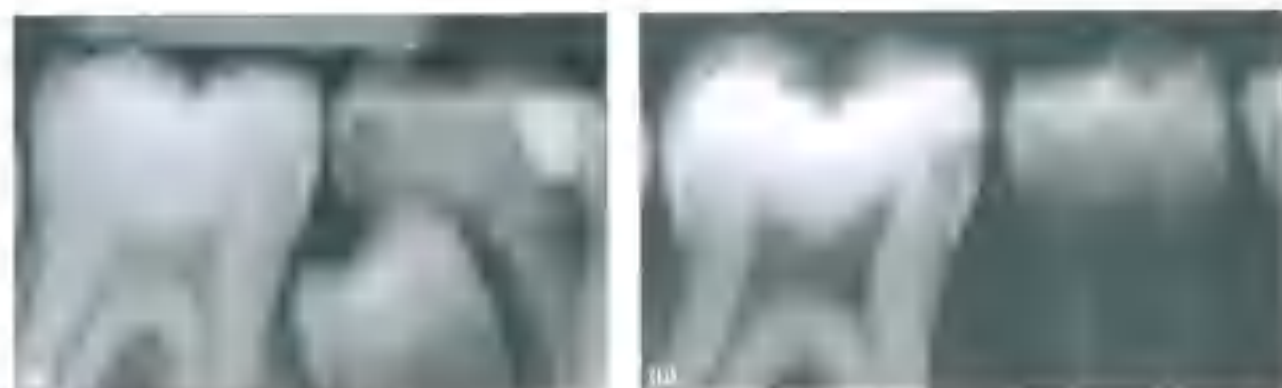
Two magnified radiographs showing caries lesion progression over 4 years in the same patient. (a) Dentin caries lesion in the distal surface of lower right primary second molar – a condition that increases the risk of caries development in the neighboring surface. (b) Four years later the second premolar had erupted and the mesial surface of the permanent first molar showed dentin caries.
